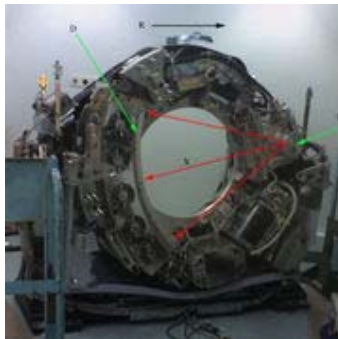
CT scanner with cover removed to show the principle of operation
